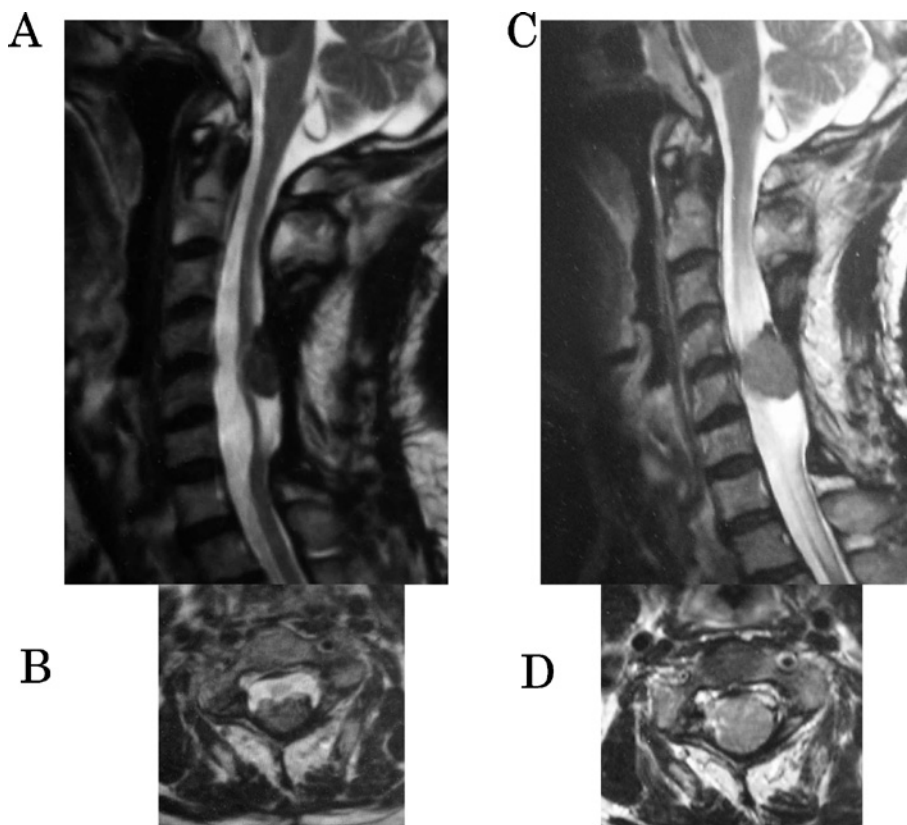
Sagittal T2-weighted (A) and axial (B) imaging showed recurrence of the tumor six months after surgery at our hospital. Sagittal T2-weighted (C) and axial (D) imaging revealed tumor growth two years after surgery at our hospital.
